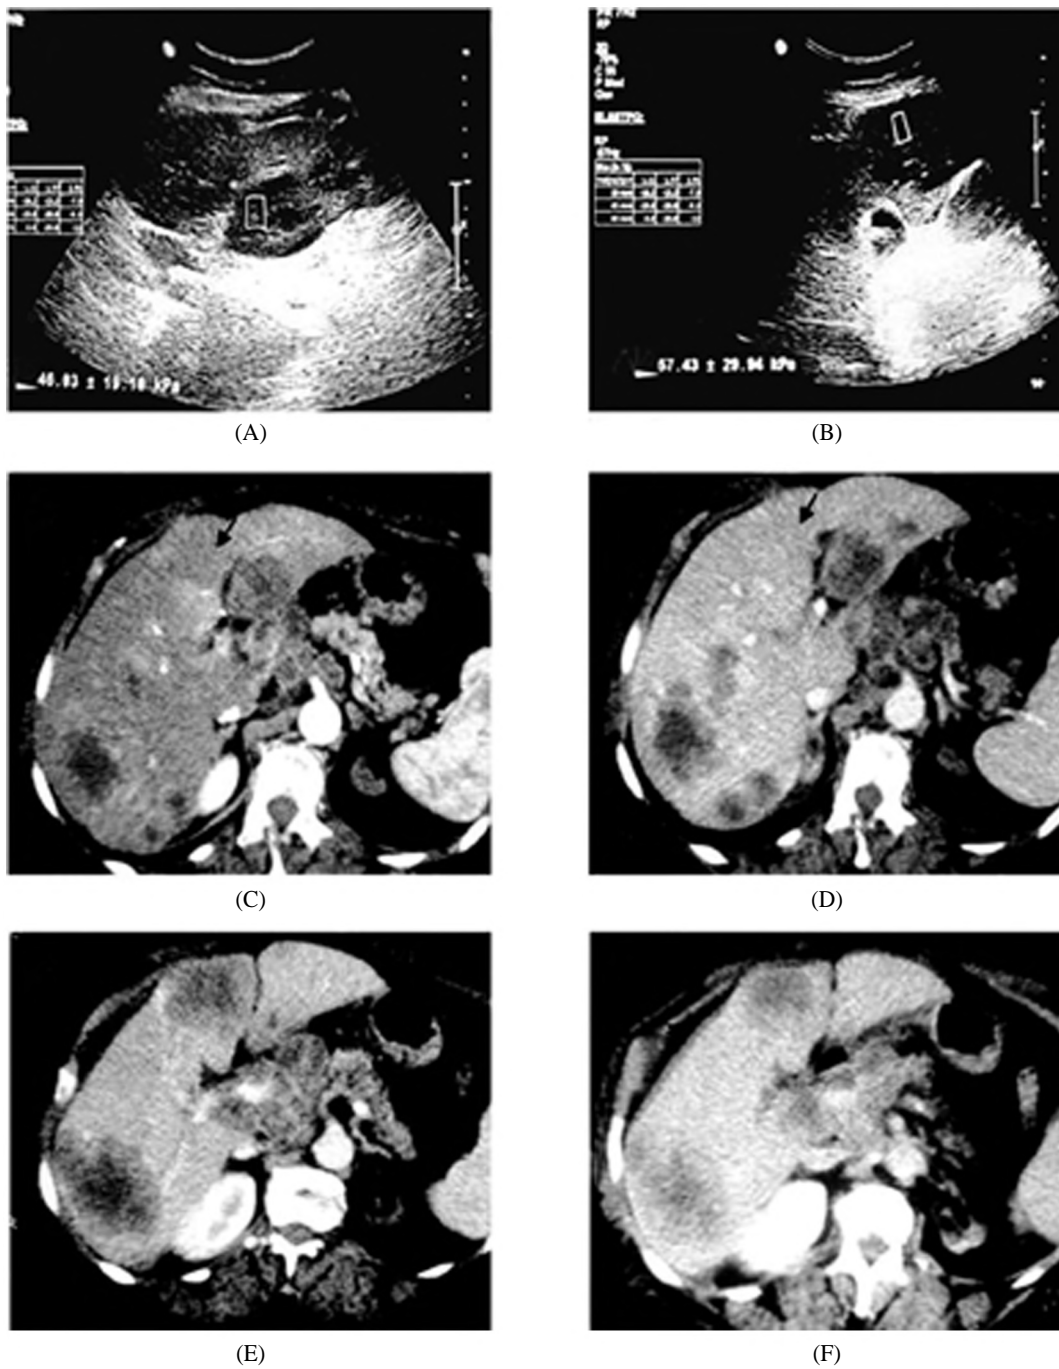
Liver metastases from pancreatic head carcinoma. 61 year old female presenting with past history of cancer head of pancreas, with bilobar variable sized hepatic hypoechoic focal lesions. (A-B) B-mode shows two well-defined hypoechoic focal lesions at segments IVa and IVb respectively, with SWE mean stiffness values (46 ± 19 and 57 ± 29 Kpa) respectively. Axial triphasic CT, showing arterial and portal phases of segments IVa (C-D) and IVb (E-F), showing peripheral thick marginal arterial enhancement with progressive enhancement in the portal phase and central non enhancing areas of break down.
